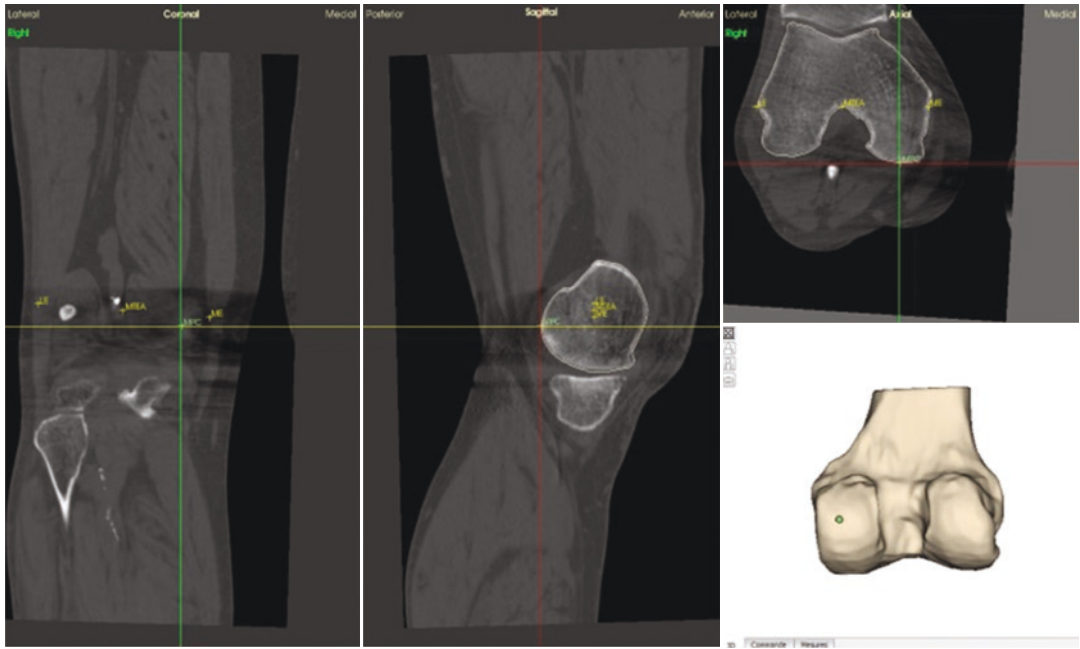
CT slices of a patient's knee and the medial posterior condyle of the tibia selected
